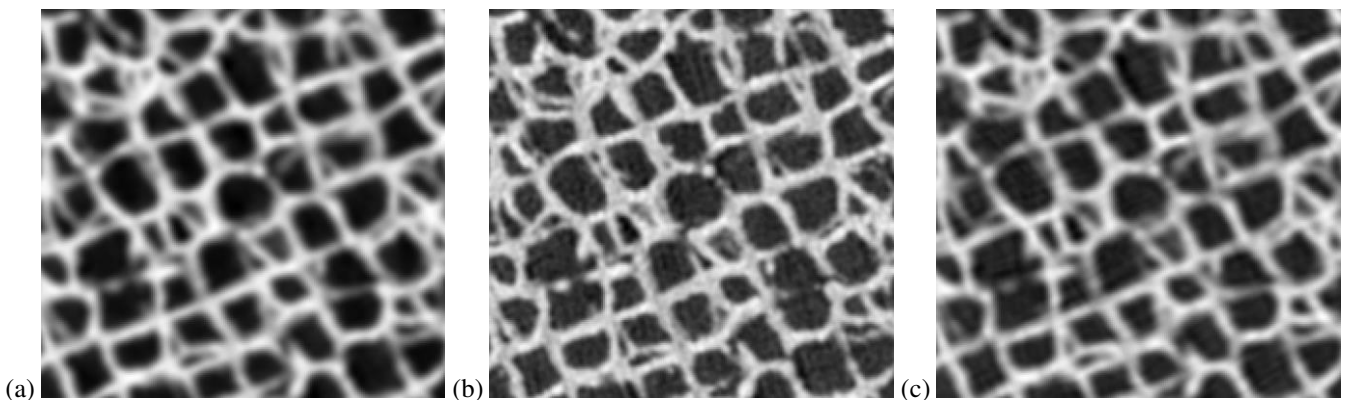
AM Lattice Cylinder Y Slice of CT reconstruction (a) baseline no deconvolution, (b) Wiener deconvolution, and (c) conjugate gradient deconvolution.
